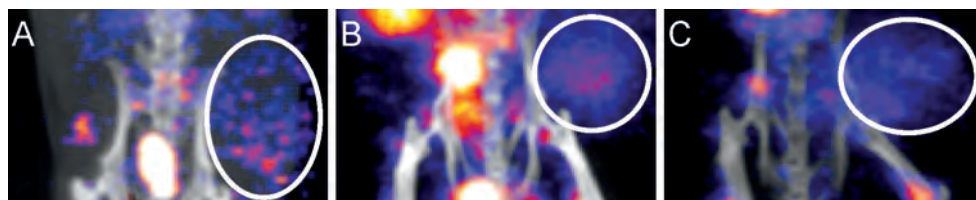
SPECT/CT of A) monomer Ac-TZ14011-MSAP, B) dimer (Ac-TZ14011)₂-MSAP and C) tetramer (Ac-TZ14011)₄-MSAP.
